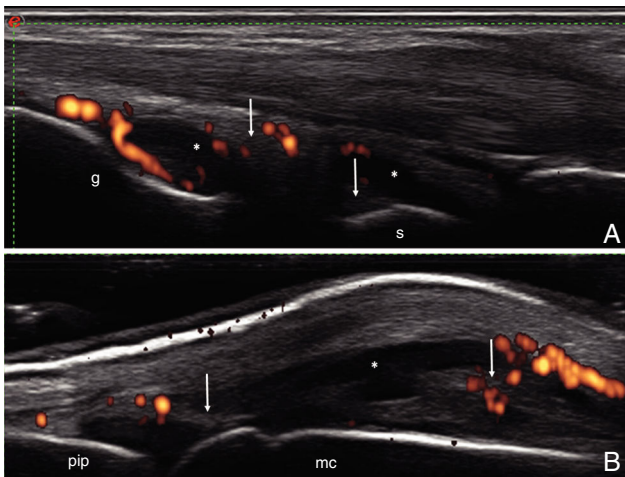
(A) Carpus. Dorsal longitudinal plane. Capsular distension in the radiocarpal and intercarpal joints recesses, both with synovial fluid (*) and areas of synovial proliferation (arrow), with increased vascularization by power Doppler (grade 2). (B) Metacarpophalangeal joint. Dorsal longitudinal plane. Joint capsular distension with areas of synovial fluid (*) and areas of synovial proliferation (arrow), with increased vascularization by power Doppler (grade 2). l, large; mc, metacarpophalangeal joint; pip, proximal interphalangeal joint; r, radiocarpal; s, semilunar.
